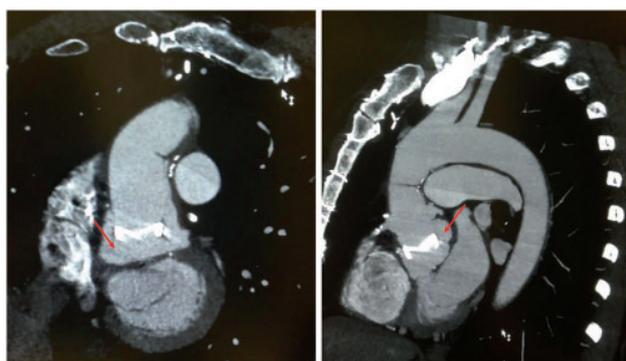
Computed tomography scans showing pseudoaneurysm formation at the proximal suture line.
